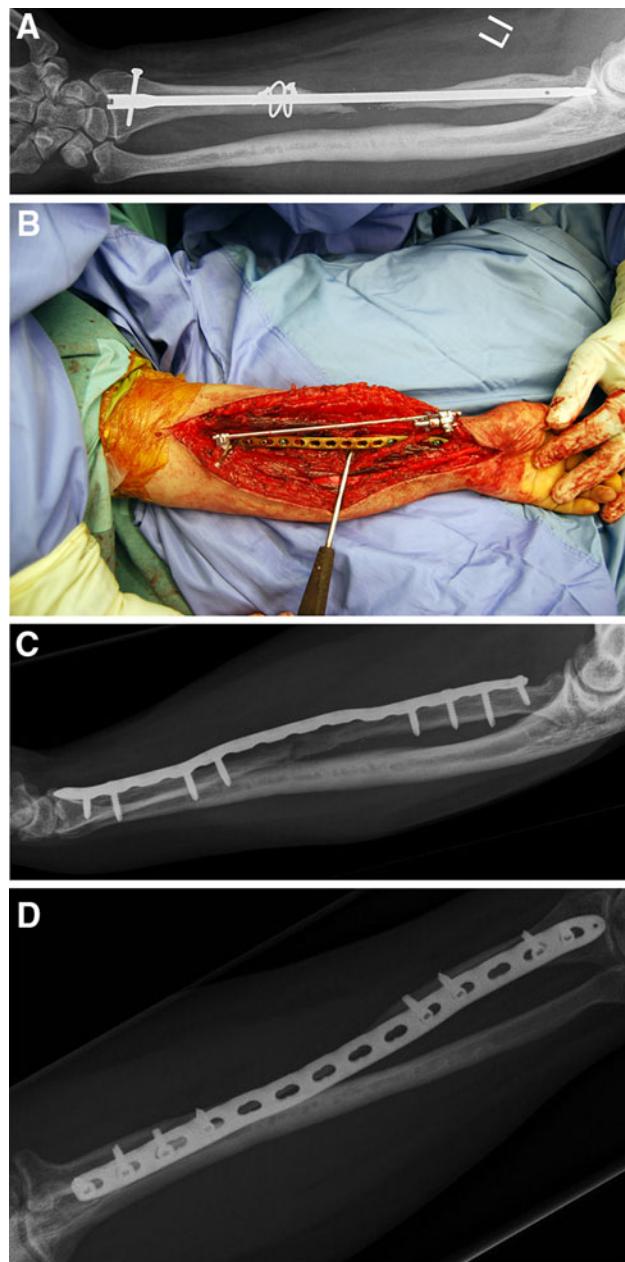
a Anterior–posterior radiograph of an atrophic radius non-union in a 38-year-old female. She had undergone multiple previous attempts to obtain union at an outside hospital. Notice the protruding pin proximally. b Wide intra-operative exposure (Henry approach), with a 3.5-mm LCP plate on the radius. Intra-operative distraction maintaining radial length was obtained with a temporary external fixator. c, d Treatment consisted of autologous corticocancellous bone grafting and 3.5-mm LCP plate fixation. Radiographs at 15 months follow-up show a healed radius
